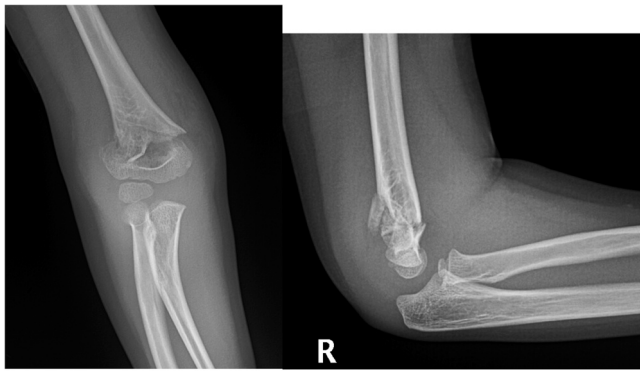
Anteroposterior (AP) and lateral elbow radiographs of a 6-year-old male who sustained a right type III supracondylar humerus fracture.
